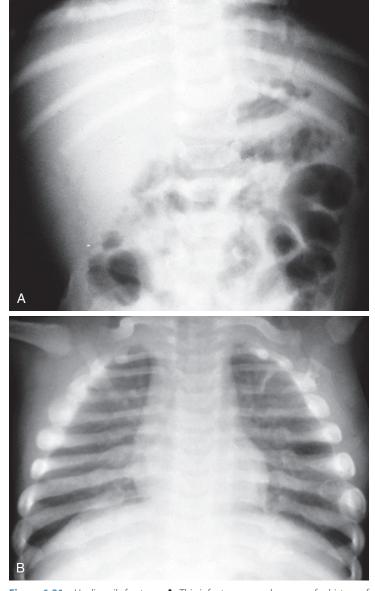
Healing rib fractures. A, This infant was seen because of a history of vomiting and irritability. An abdominal film obtained to rule out intestinal obstruction showed a normal bowel gas pattern but revealed posterior rib fractures in the early stages of healing. Note the vertical lucencies surrounded by soft callus. The fractures were missed. B, When the infant was finally tracked down 2 months later, her chest radiograph showed in excess of 20 healing rib fractures, some posterior and others lateral and anterolateral. The exuberance of the callus in many places reflects repetitive reinjury. Some of these were palpable clinically. (*Courtesy Department of Radiology, Children's Hospital of Pittsburgh, Pa.*)
